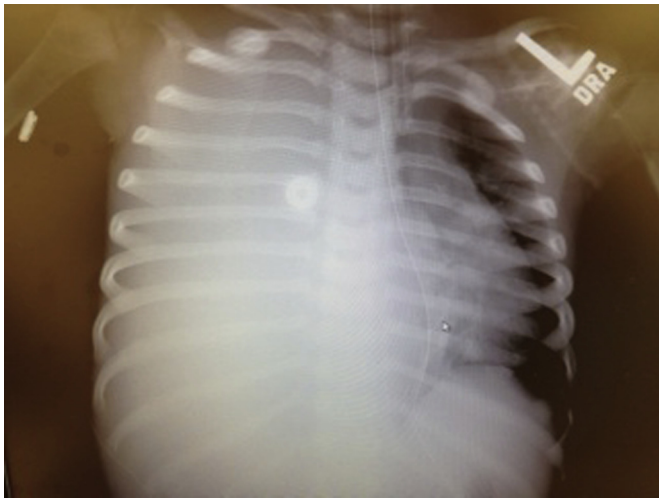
Initial chest x-ray during trauma evaluation.
